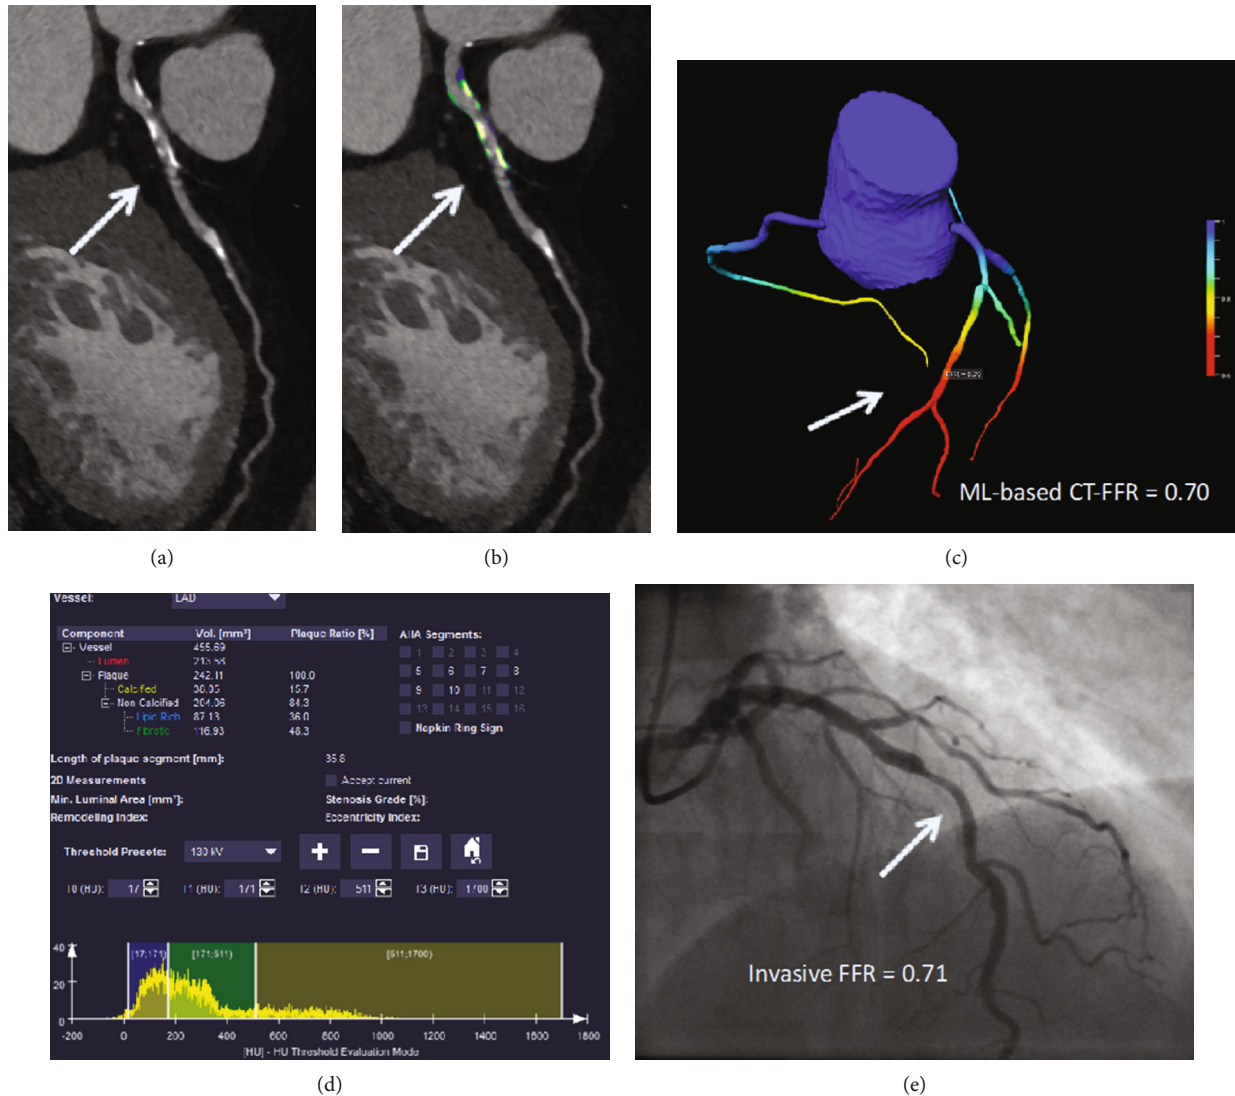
Coronary CT angiography in a 54-year-old man without known coronary artery disease. (a) Automatically generated curved multiplanar reformations showing  $>50\%$  stenosis of the proximal LAD (arrow). (c) 3-Dimensional color-coded mesh shows a CT-FFR value of 0.70, indicating ischemia of the underlying stenosis (arrow). (b, d) Color-coded automated plaque assessment of the lesion demonstrating the predominantly calcified composition of the atherosclerotic atheroma. (e) Invasive coronary angiography confirms obstructive stenosis of the LAD (arrow) with an FFR of 0.70.
